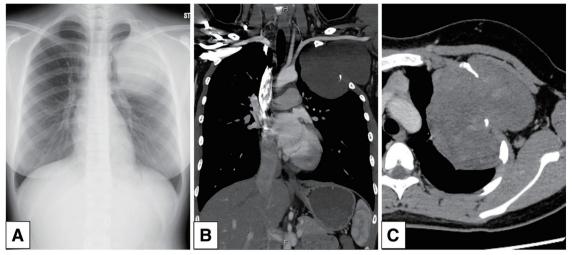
Preoperative (A) chest X-ray film and (B) and (C) computed tomography images showing a 12-cm-sized chest wall tumor surrounding the second left rib, extending from the first to the fourth rib, and abutting the subclavian artery.
